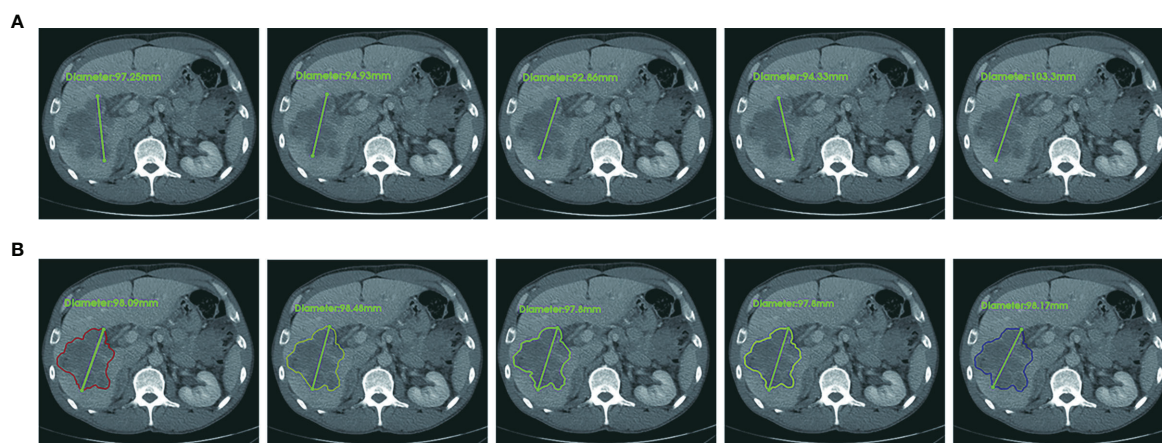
An example case of manual and CAC measurements. In terms of RECIST 1.1 criteria, the longest diameter of a target lesion is measured on the image acquisition plane (axial plane in CT). (A) Upper row: five manual measurements showed the mean value 96.5 ± 4.1 mm, range 92.7 mm to 103.3 mm, CV (coefficient of variance) 4.3%. (B) Lower row: five CAC measurements showed the mean value 98.1 ± 0.3 mm, range 97.8 mm to 98.1 mm, CV 0.3%. The agreement of CAC measurements was substantially better than that of manual measurements.
